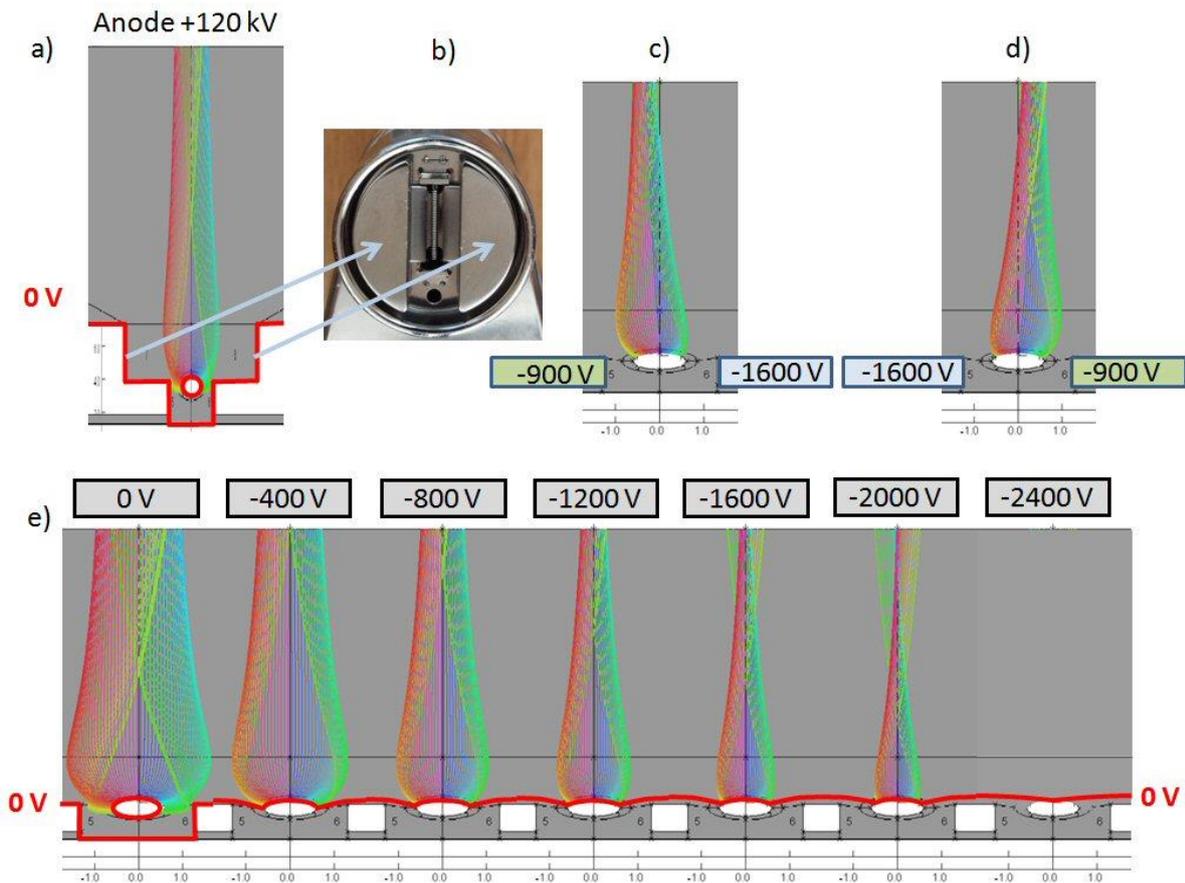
Ray tracing of electrons. Planar cross section through the emitter coil. Biasing of the control electrodes allow for focal spot deflection, as used in CT application, and also for switching the electron beam off.
